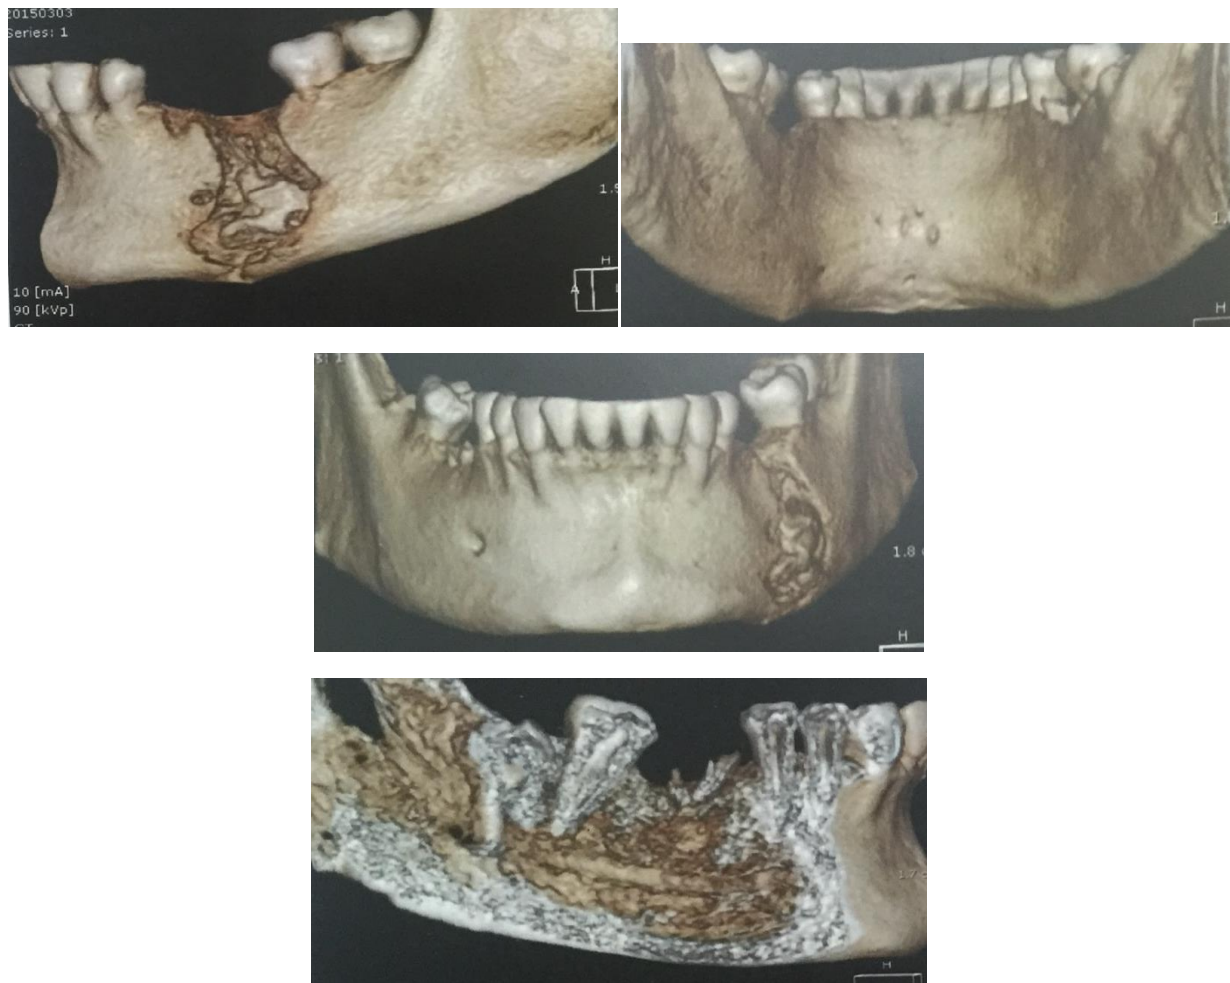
Pre operative CBCT scan
